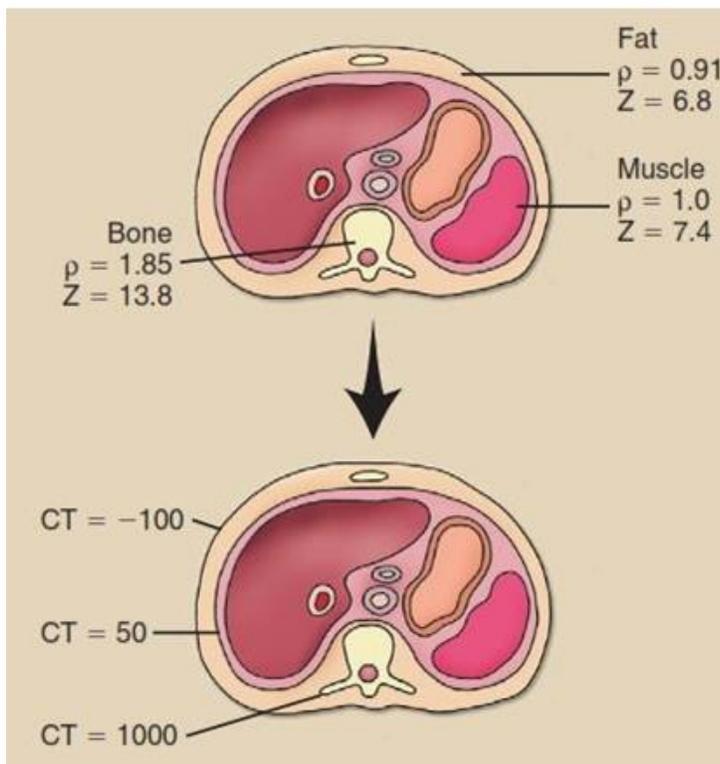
No large differences are noted in mass density and effective atomic number among tissues, but the differences are greatly amplified by computed tomography imaging.
